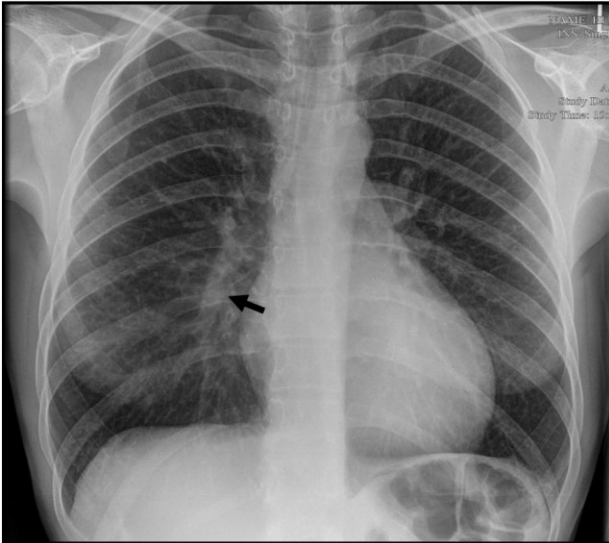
Chest radiograph showing (black arrow) prominent right descending pulmonary artery (Palla's sign).
